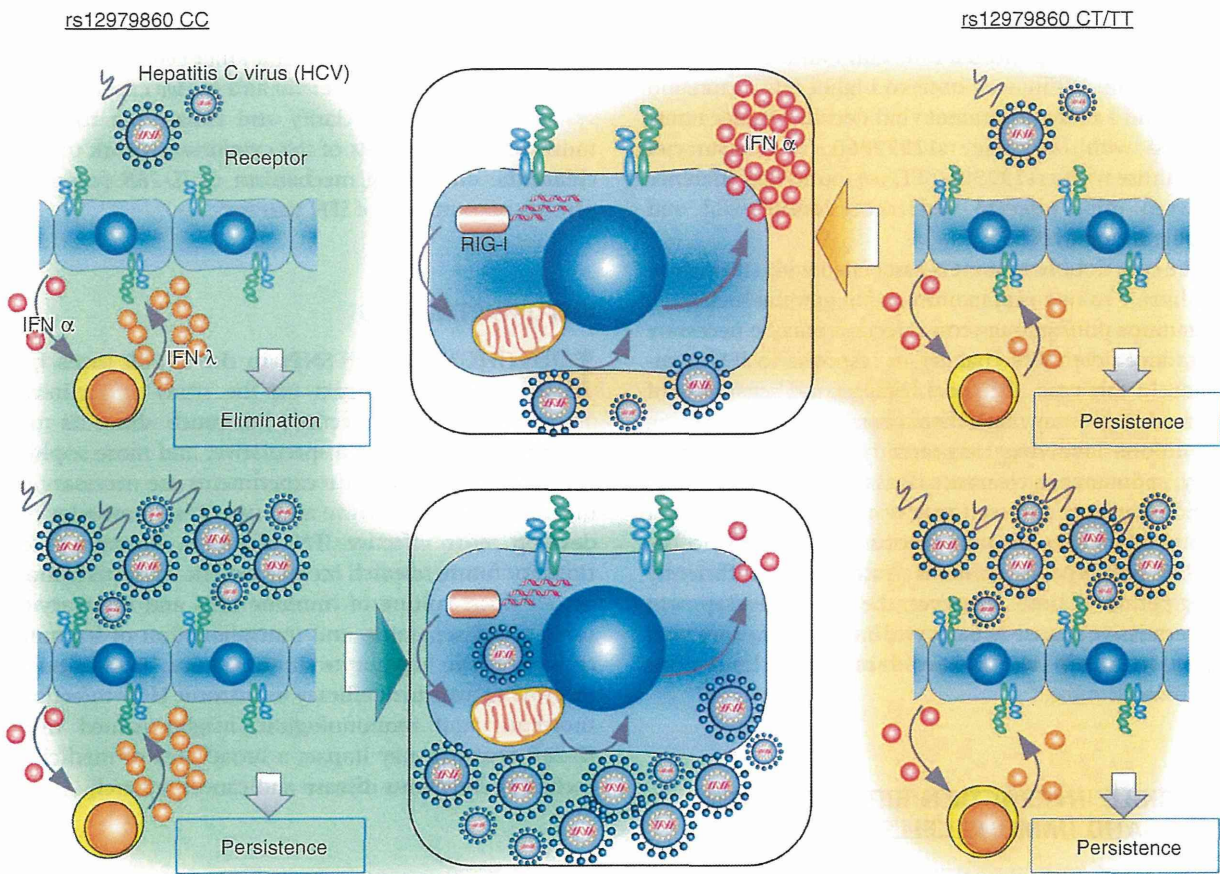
Hypothetical model of virus replication in hepatocytes with eradication-favorable (interleukin [IL]-28B rs12979860 CC or rs8099917 TT) or unfavorable (rs12979860 CT/TT or rs8099917 GT/GG) genotypes. HCV may be eliminated from individuals with the favorable genotype at low titer but may persistently infect those with high titers or the unfavorable genotype (upper right and left panels). Viral sensors continuously detect viral RNA during chronic infection (central panel), resulting in continuous activation of interferon-stimulated genes (ISG), including interferon inhibitory molecules such as *PIAS* and *SOCS3*. In hepatocytes with the unfavorable genotype, ISG expression may be refractory to further interferon stimulation, resulting in a poor response to therapy, but in hepatocytes with the favorable genotype, low baseline ISG expression may prevent overexpression of interferon signal inhibitors, resulting in stronger ISG induction and a better response to therapy.
